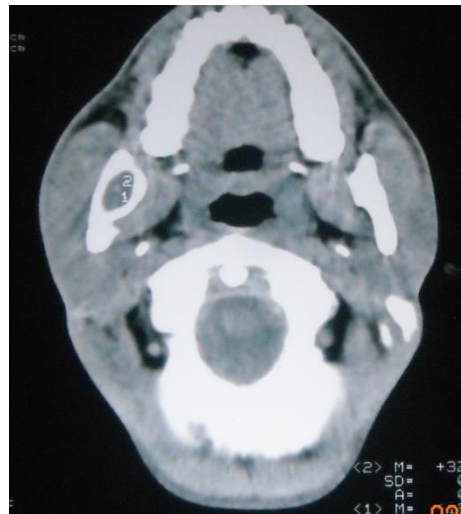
Axial section of CT scan
